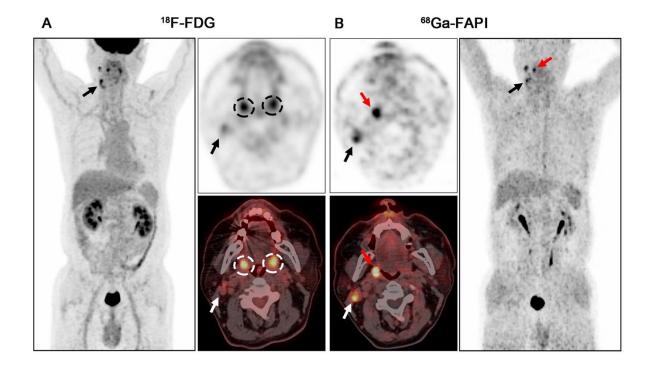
PET/CT scans with the  $^{18}$ F-FDG (A) and  $^{68}$ Ga-FAPI (B) in a 63-year-old male patient (patient 2) with metastatic squamous cell carcinoma (SCC) of the right neck.  $^{18}$ F-FDG-PET/CT was negative for the detection of the primary. The increased uptake of FDG was detected in palatine tonsils of both right and left sides (A, black and white dashed circles; SUV<sub>max</sub> = 6.40 and 6.00, respectively), resulting an SUV<sub>max</sub> ratio of 1.07. On  $^{68}$ Ga-FAPI-PET/CT, there was asymmetric fullness with intensive uptake in the right palatine tonsil (B, red arrow; SUV<sub>max</sub> = 8.30), while low background uptake was seen in the left palatine tonsil (SUV<sub>max</sub> ratio = 3.46). Subsequent tonsillectomy confirmed SCC. Black and white arrows indicate the metastatic lymph nodes.
